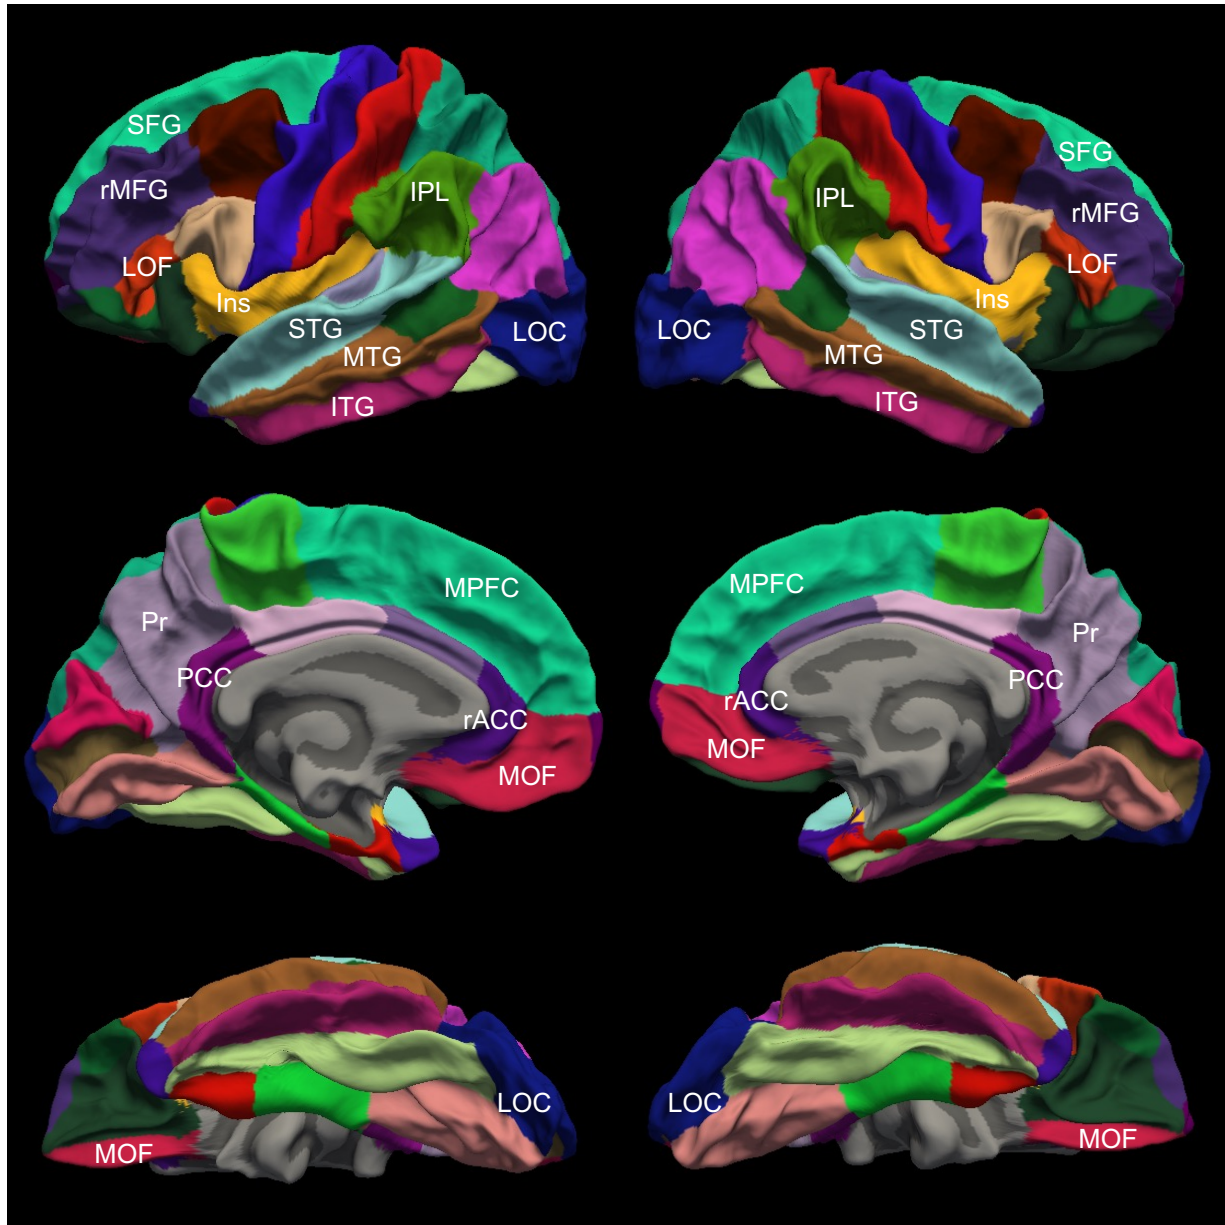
Regions of Interest for Cortical Thickness, TSPO PET-MRI, and Tau PET-MRI Analyses.
